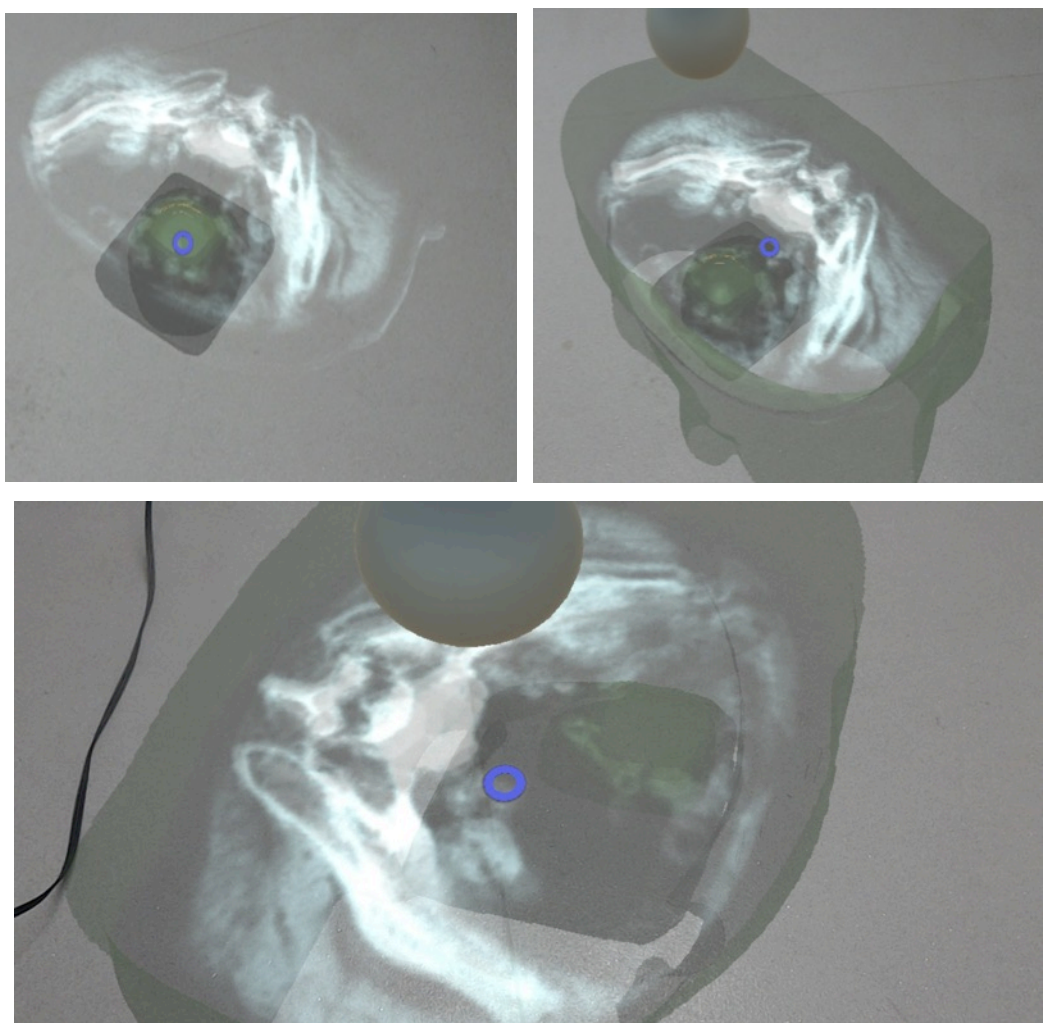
Rudimentary technique to produce volume rendering effects by render semi-transparent rendering of sections of the CT dataset corresponding to transverse CT slices covering segments of the vertical axis of 3 cm length. Isodose surface for 95% of prescribed dose and PTV outline is also rendered. The sphere is a hand-draggable light source used to provide some control over luminosity and contrast of the CT dataset rendering.
